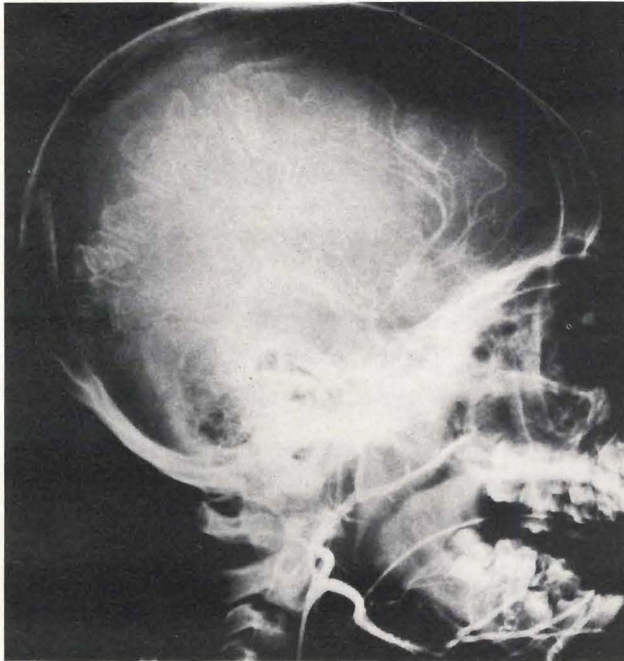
Lateral head roentgenogram of the patient. The iodinated contrast material can be seen in the right lingual artery and its branches. Also note the classical intracranial calcifications, which resemble railroad tracks.
